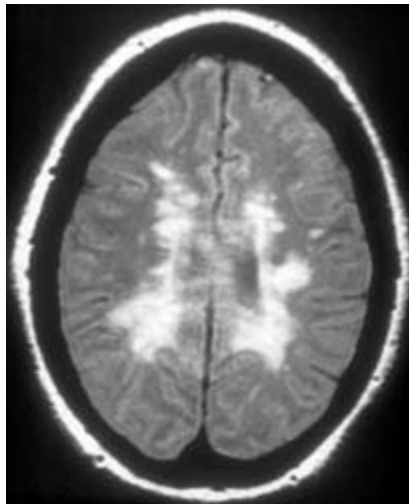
Unenhanced MRI scan showing the presence of MS plaques. Image courtesy of Gordon Sze, MD.
